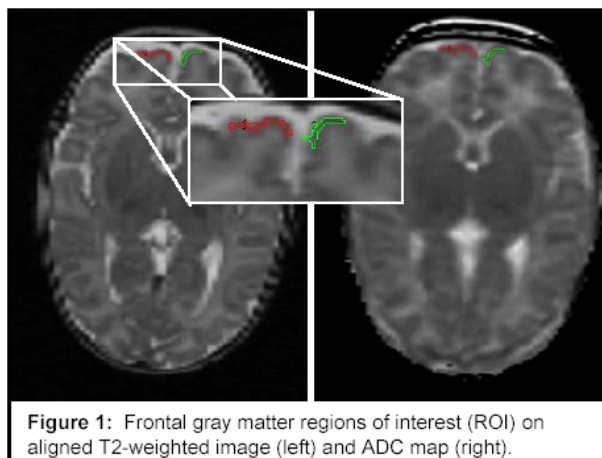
Frontal gray matter regions of interest (ROI) on aligned T2-weighted image (left) and ADC map (right).
